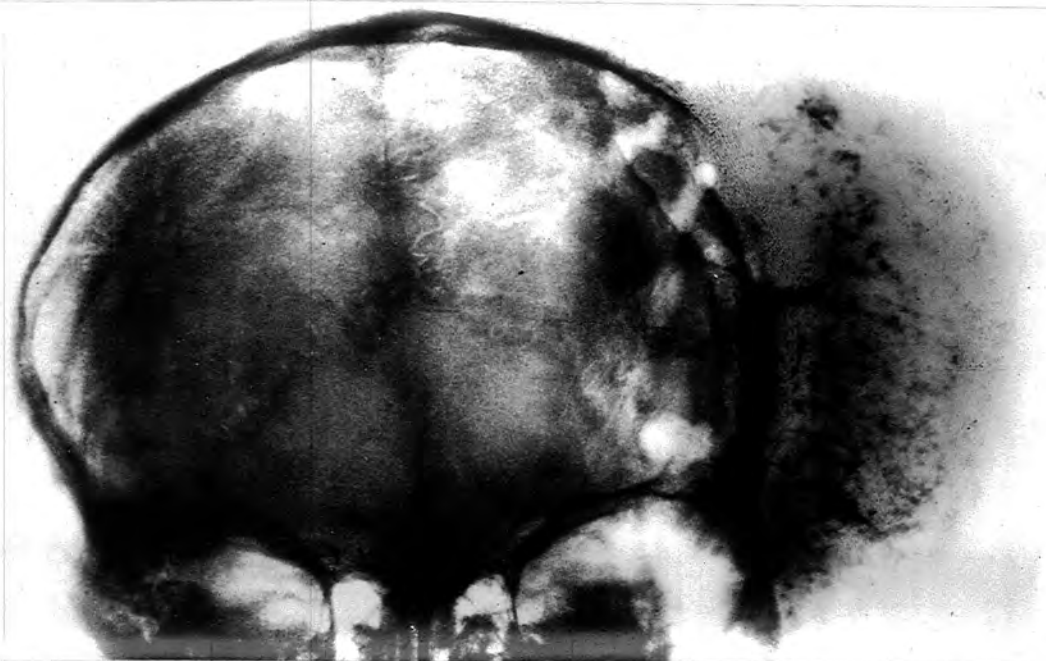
CASE FOUR. X-ray of skull, axial view. Note calcification within soft tissue shadow and the enlarged vascular channels.
